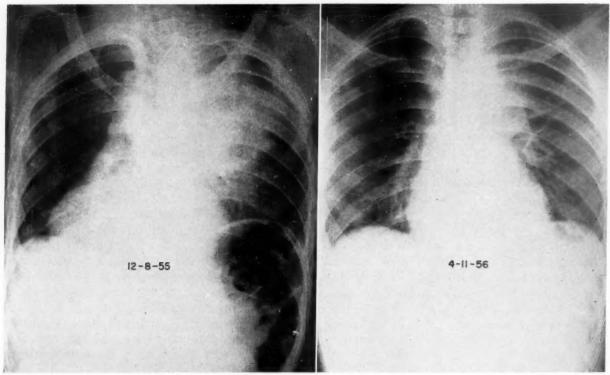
Young Negro man with severe back pain of one year's duration recently accompanied by fever. Chest roent-genograms disclosed a homogeneous infiltration in the left upper lung field with marked mediastinal widening most marked inferiorly (*left*). Roentgenograms of the spine showed involvement of the mid-thoracic vertebrae. The mediastinal abscess pointed posteriorly. Surgical drainage produced considerable pus from which A. bovis was cultured. On vigorous prolonged penicillin therapy, augmented for several months with sulfadiazine and body cast, healing gradually ensued (*right*). From: Peabody, J. W., Jr. and Seabury, J. H. Actinomycosis and nocardiosis. *J. Chron. Dis.*, 5: 374, 1957.
